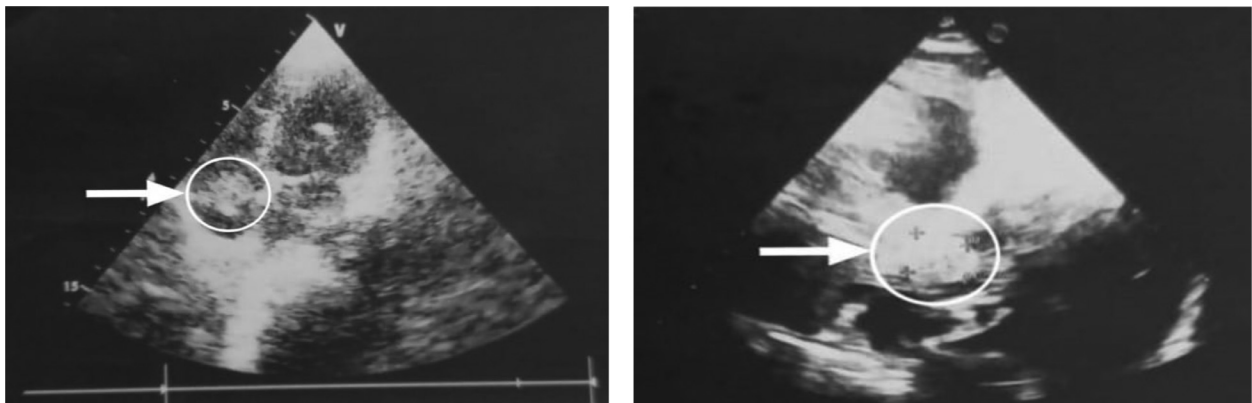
(A and B) Echocardiogram showing right atrial myxoma connected via a stalk to the interatrial septum.
